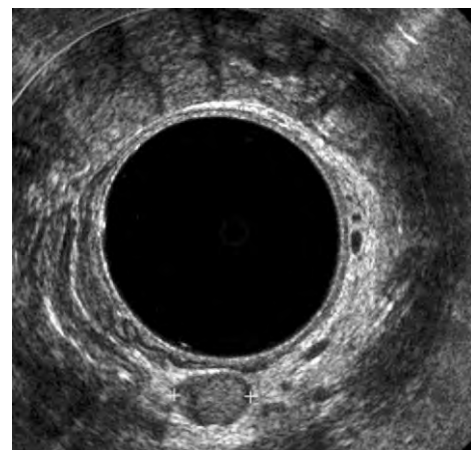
Metastatic lymph node (1.2 cm) detected with endorectal ultrasound.
